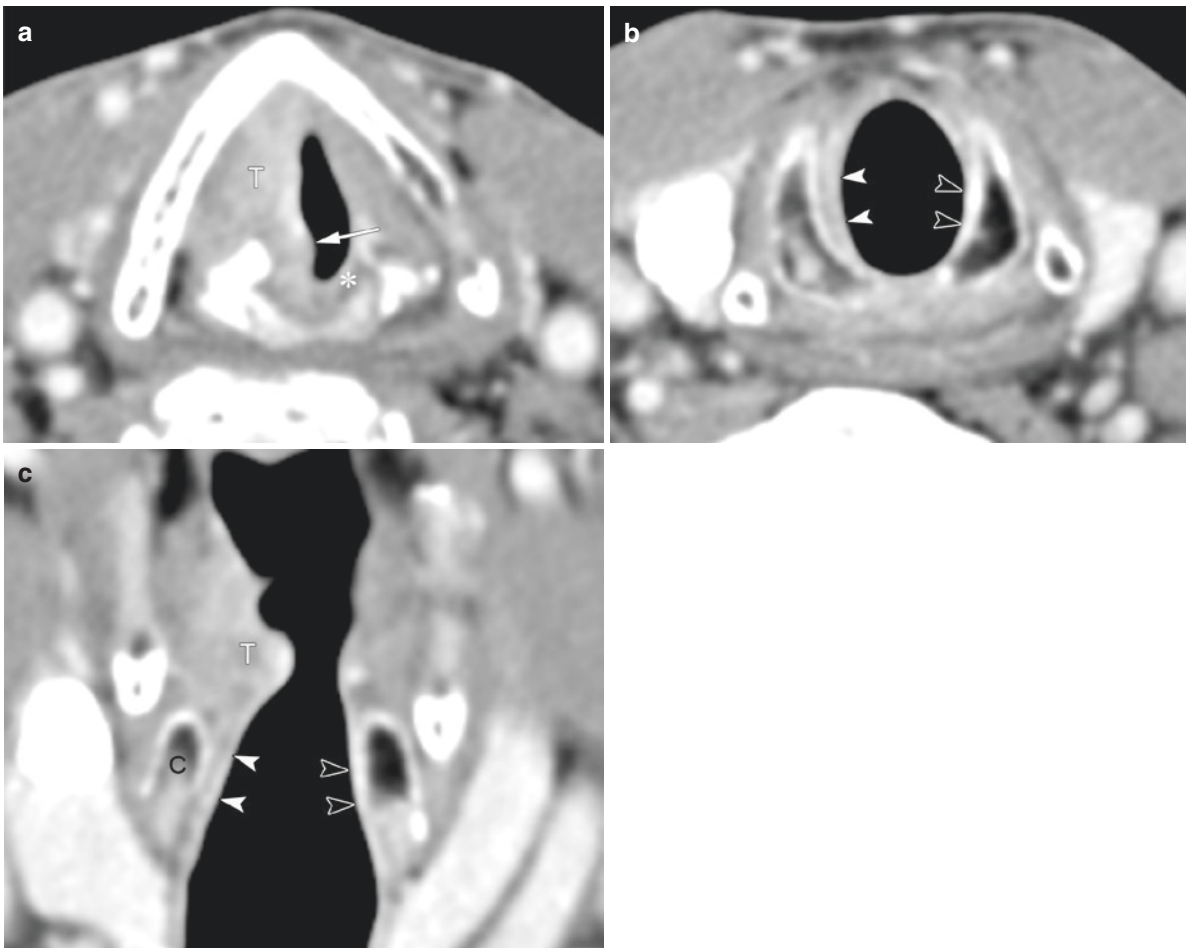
Subglottic extension of a glottic carcinoma (T3). Axial contrast-enhanced CT image (a) demonstrates a tumor (T) of the right glottis with infiltration of the paraglottic space, arytenoid area, and cricoid area (arrow). Note the fat tissue of the cricoid area at the normal left side (asterisk). Axial image at the cricoid level (b) and coronal
